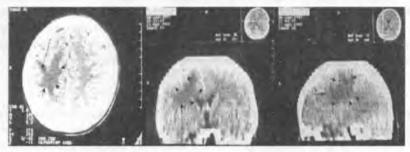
Head CT revealed small, 22 mm in diameter, lesion with contrast enhancement with surrounding area of local brain swelling, in right parietal lobe, suggestive of brain tumor
